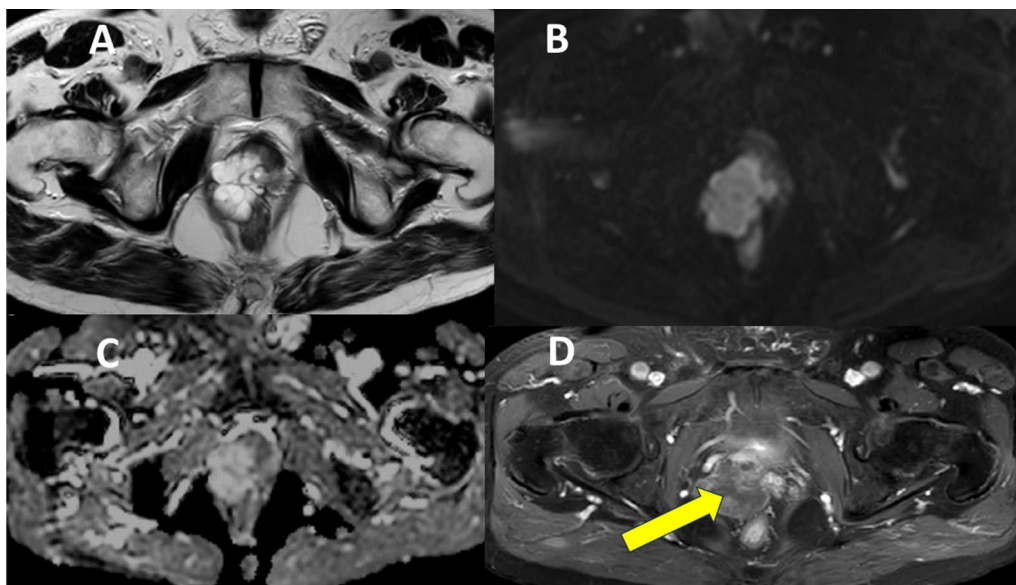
A Axial T2 sequence demonstrating a multiloculated mass, hyperintense to the surrounding PZ, and with irregular and non-continuous hypointense septa, extending into the posterior periprostatic fat reaching the rectum and the bladder walls. B–C On axial high-b value DWI, sequence of the prostatic mass appears hyperintense. C The ADC map shows high signal intensity in the mucoid matrix and medium-to-low signal intensity in the septa. D DCE-MRI sequence of the prostate demonstrating inhomogeneous enhancement of the lesion's septa
